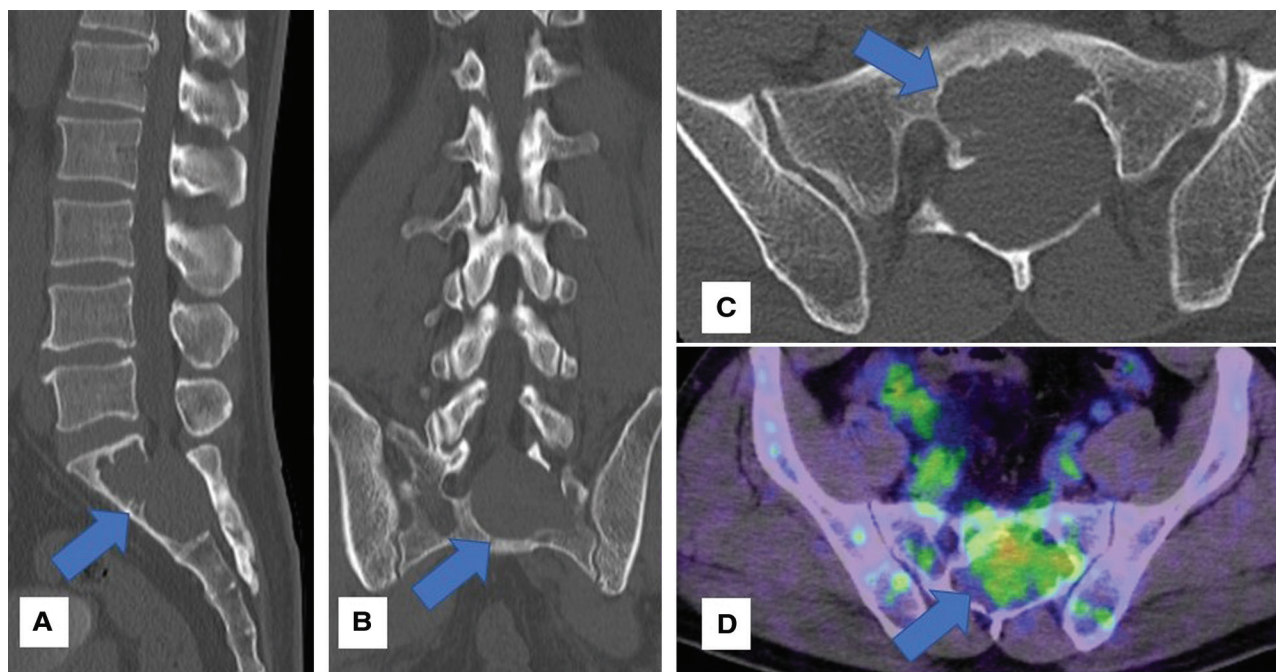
CT scan revealed irregular bone destruction of the sacrum with a thin sclerotic rim, suggestive of benign nature (A–C, arrow). ^{18}F -FDG PET showed low uptake of FDG corresponding to the CT findings (D, arrow). ^{18}F -FDG PET: ^{18}F -fluoro-deoxy-glucose positron-emission-tomography, CT: computed tomography.
